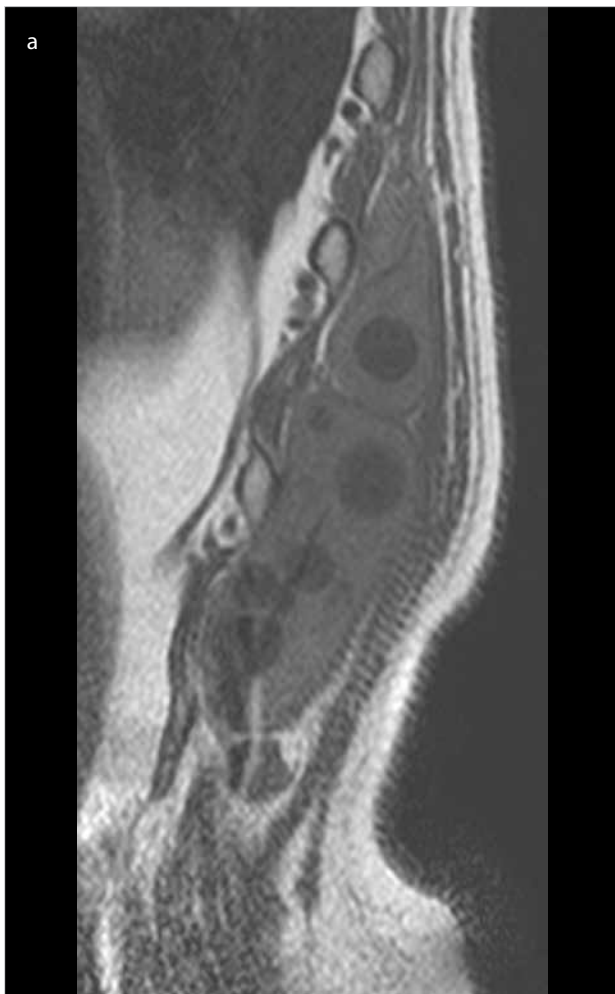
a-c. (a) Sagittal T1-weighted and (b) axial T2-weighted fat-suppressed images show a well-defined paraspinous mass in the left lumbar region with small, well-circumscribed, round cysts. (c) On axial post-contrast fat-suppressed T1-weighted image, the lesion shows peripheral enhancement
